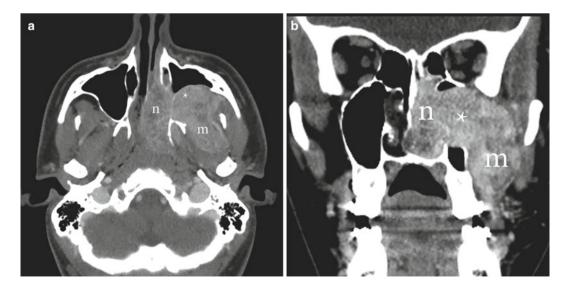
Juvenile nasopharyngeal angiofibroma. Axial (a) and coronal (b) contrast-enhanced CT (CECT) images demonstrate an avidly enhancing mass extending from the nasal cavity (n) into the masticator space (m) via an enlarged pterygopalatine fossa (*asterisk*)
